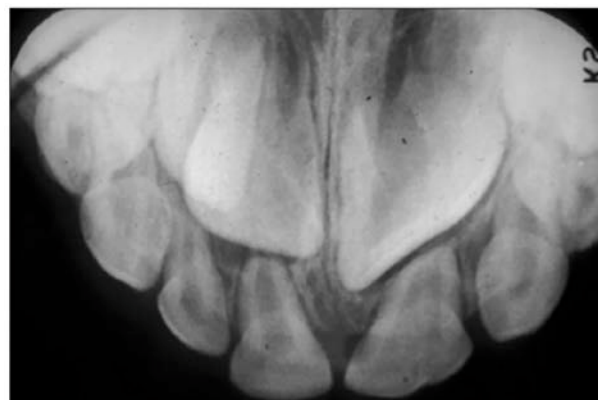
Periapical radiograph of fused primary teeth F & G and permanent teeth #9 & #10. Note the larger fused crown size.
